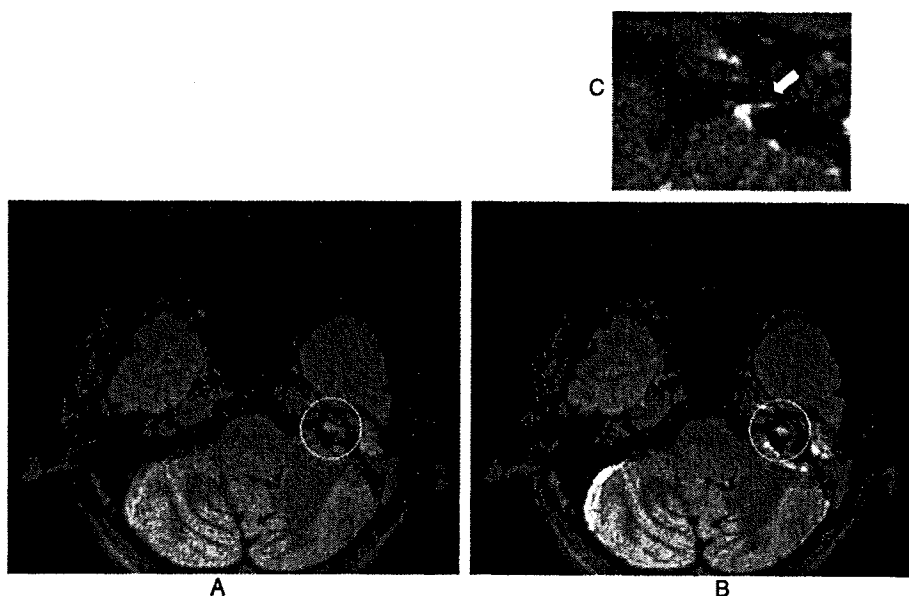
3D-FLAIR images of Case 1. A, B. Pre-contrast (A) and post-contrast (B) inner ear lesions (circled). The inner ear is morphologically abnormal because of partial ossification. C. High-magnification image of enhancement in the cochlear aqueduct (arrow).
